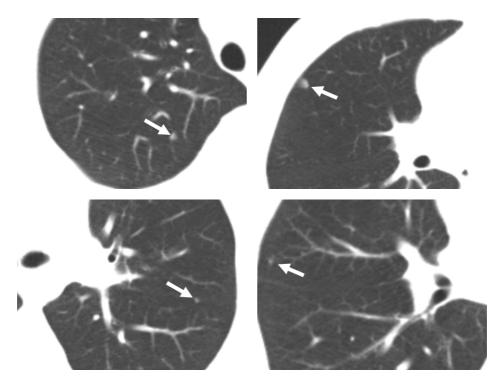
Interstitial lung disease on high-resolution computed tomography (HRCT). Fourteen-year-old male CVID patient with a history of systemic lupus erythematosus and vitiligo, severely reduced memory B cells but relatively high numbers of CD8+T lymphocytes. Pulmonary symptoms are limited to upper respiratory tract infections and allergic rhinitis. Four zoomed HRCT images at inspiration demonstrate the small lung nodules that were visible in this patient (*arrows*).
